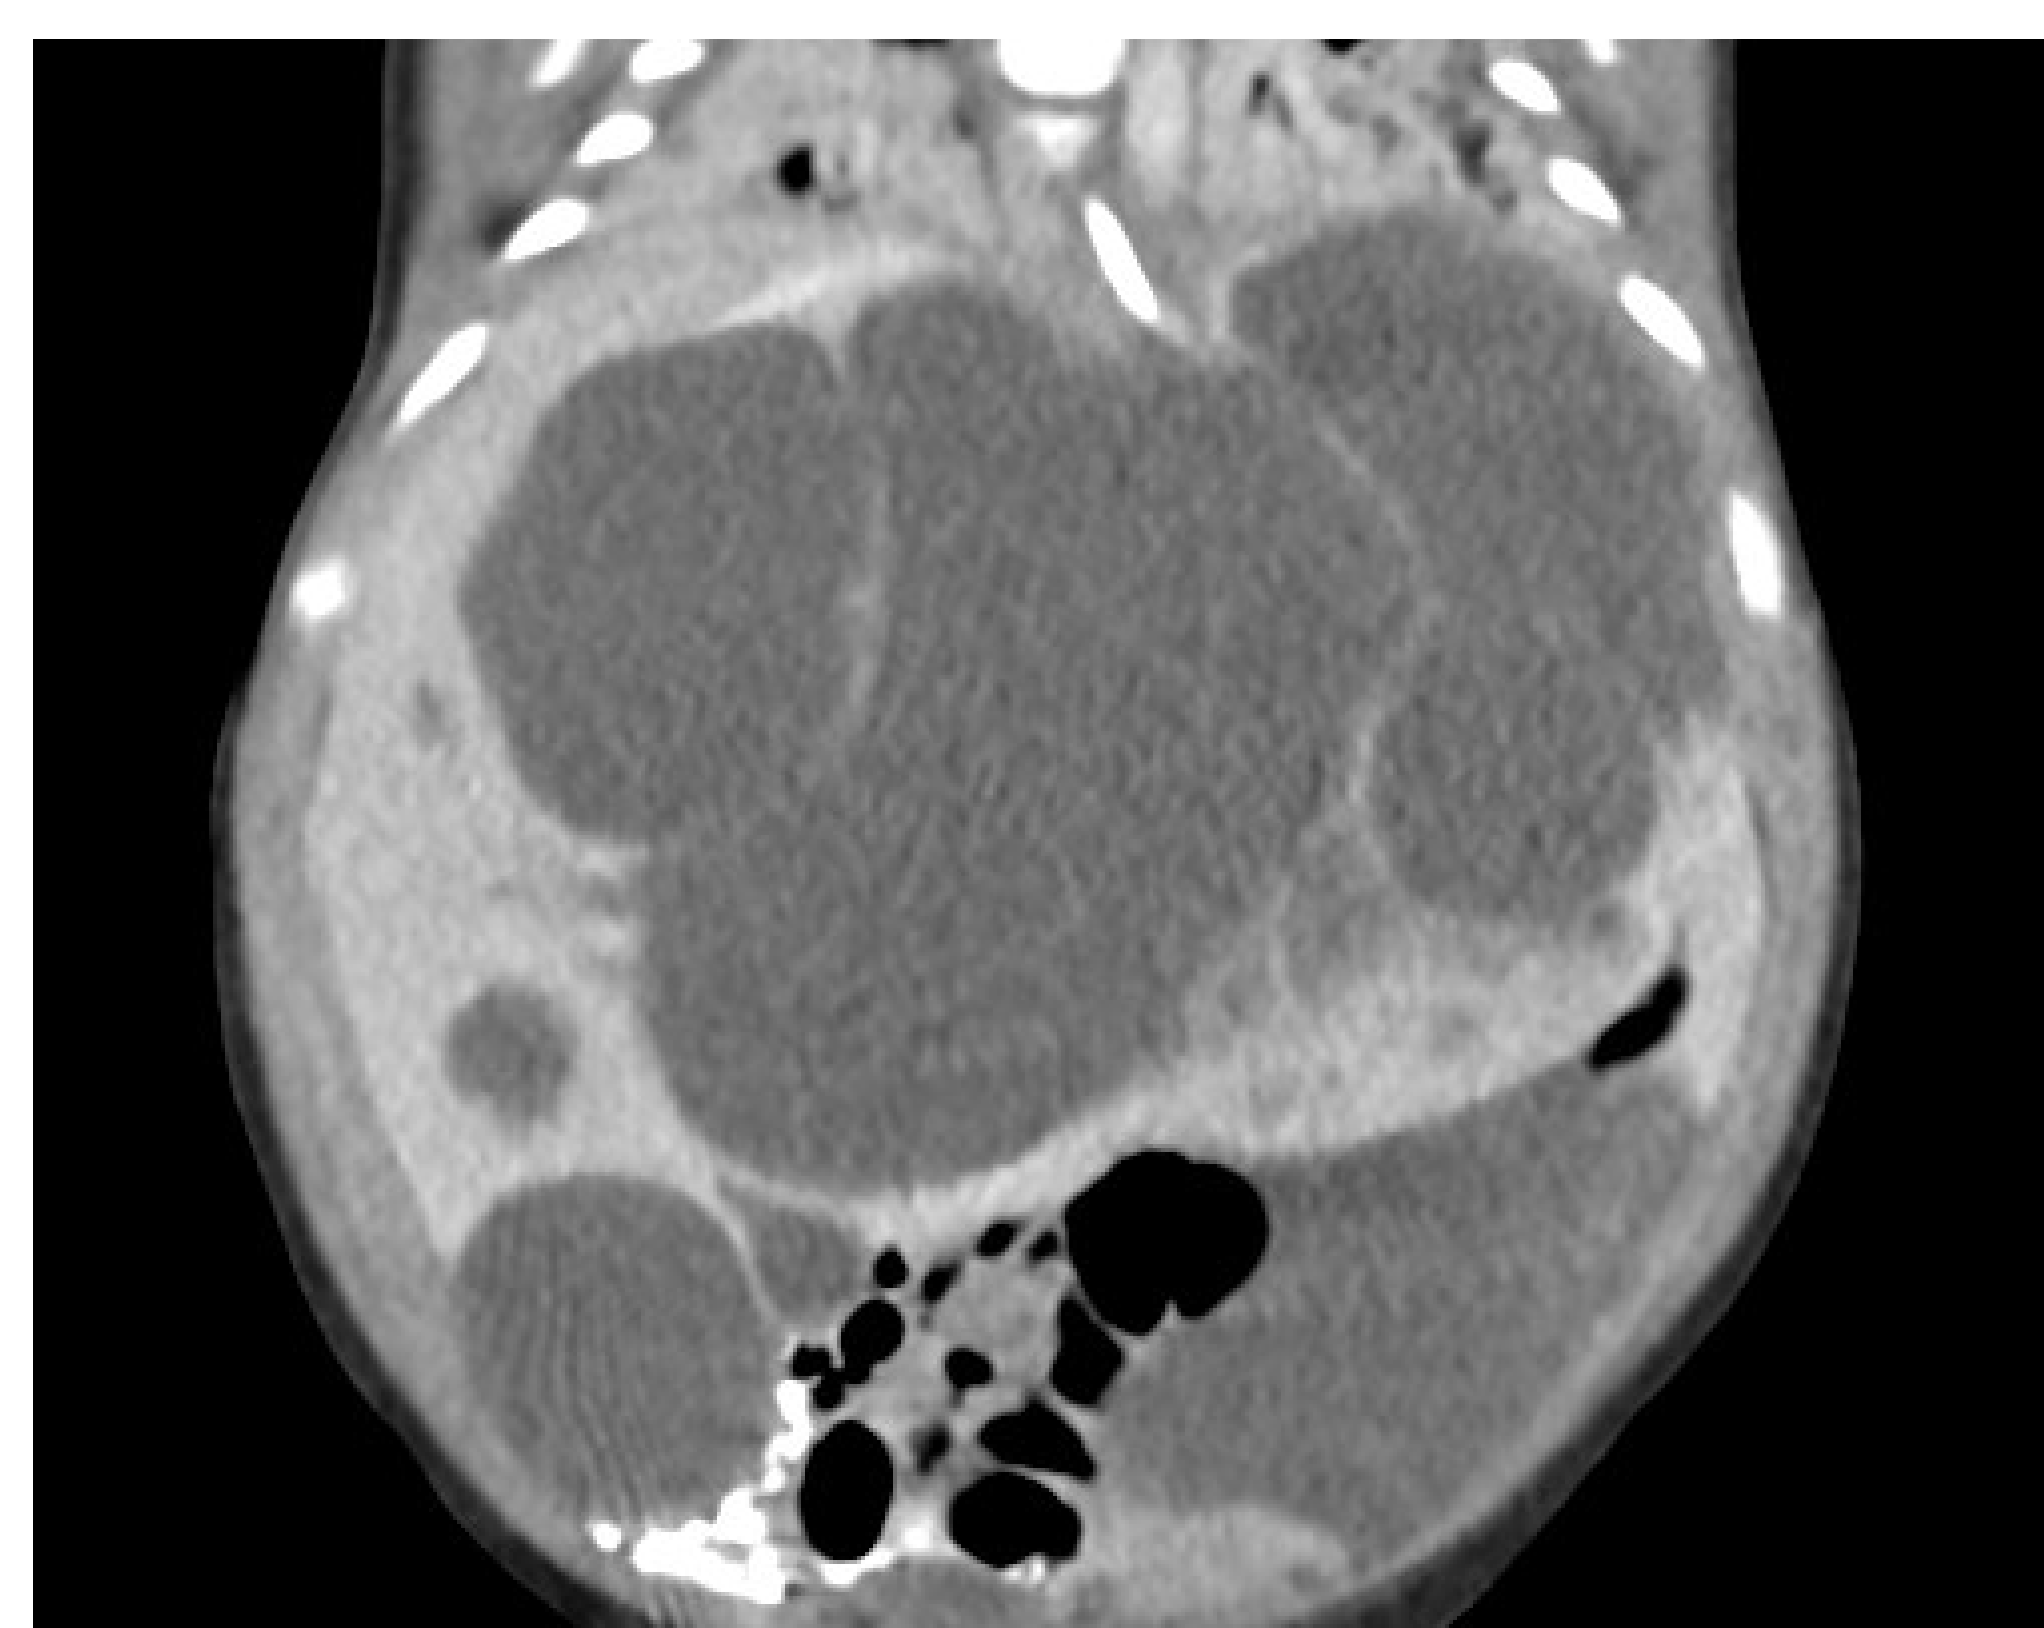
Coronal enhanced CT demonstrates multiple non-enhancing fluid attenuating cysts in the liver causing mass effect.
